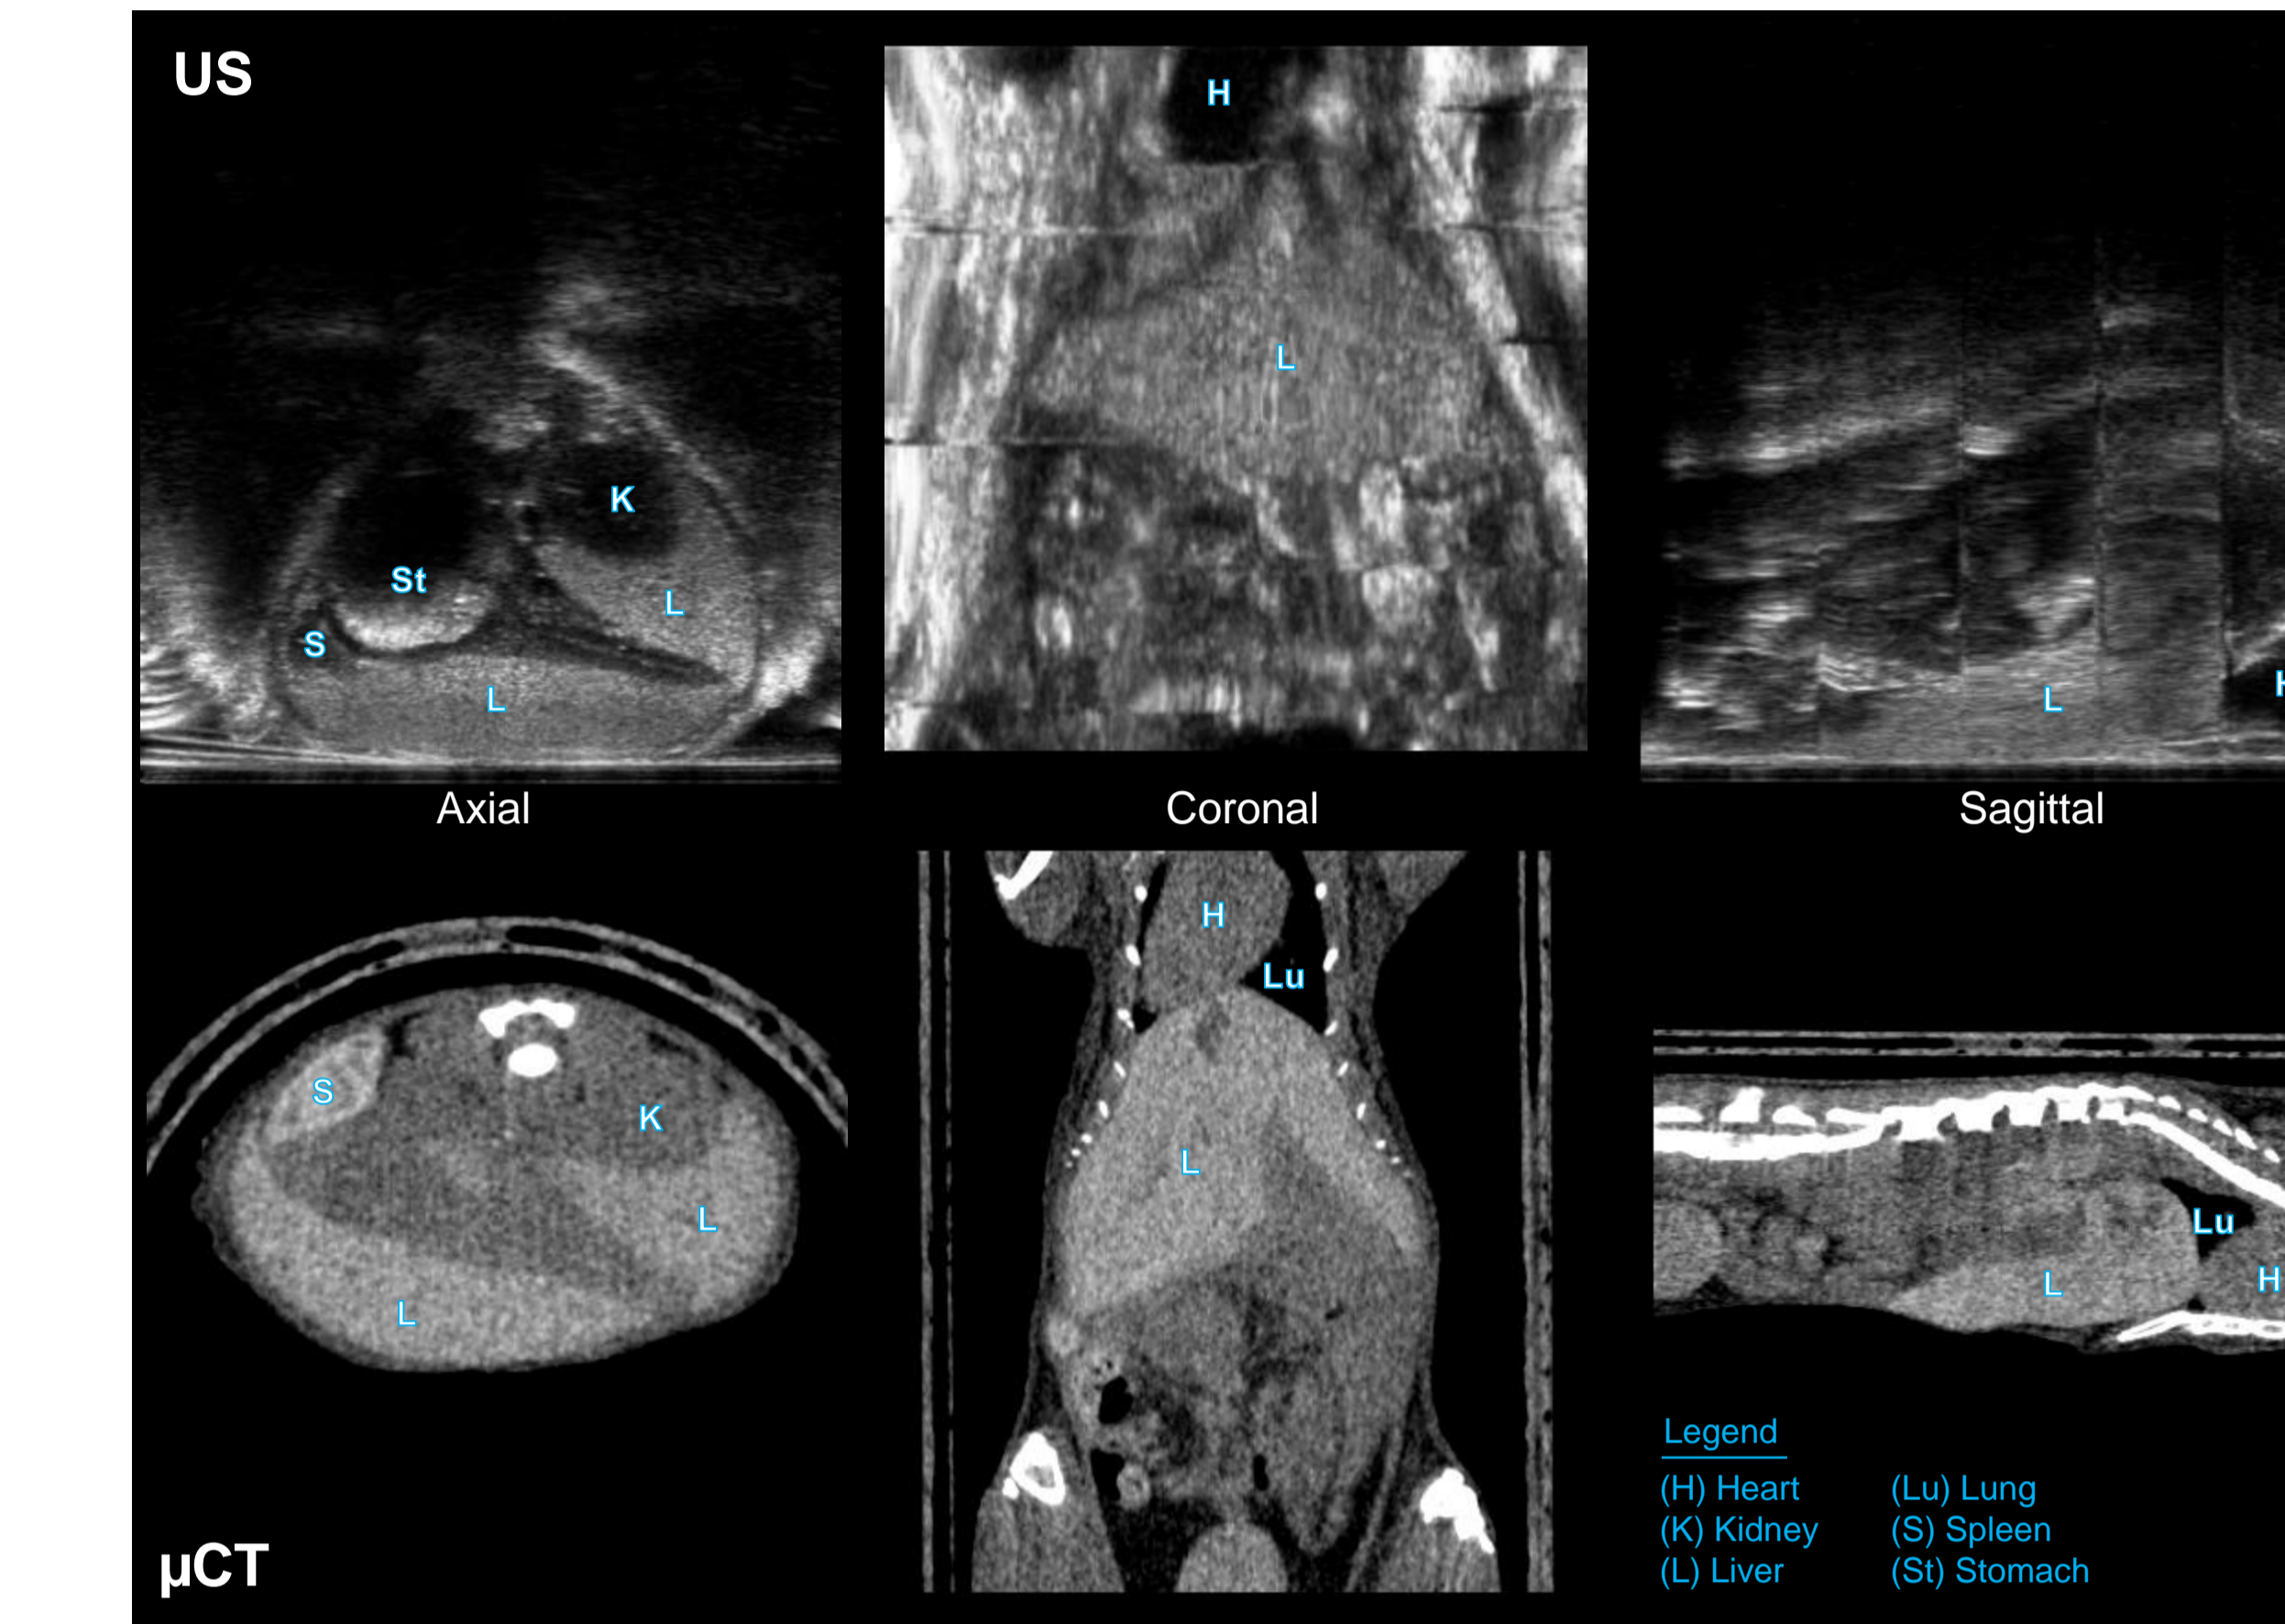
Comparison of *in vivo* liver volumetry performed by 3D US imaging and contrast-enhanced (CE) μ CT imaging. Although CE- μ CT offers superior resolution and is less prone to artifacts, strong agreement was observed between both modalities. Steatosis in the liver acts as an endogenous contrast enhancer in US, resulting in improved border definition.
